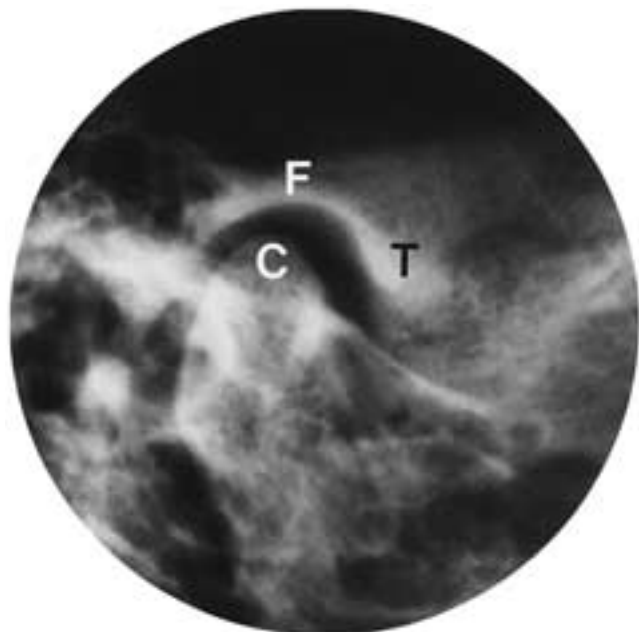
Transcranial radiograph of TMJ. The condyle (C), fossa (F), and tubercle (T) are indicated.
